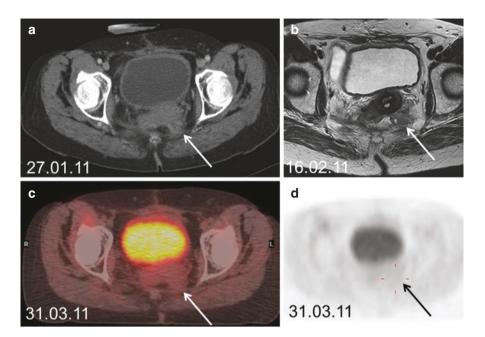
Role of FDG PET-CT in recurrent colorectal cancer. 61-year-old female with rectal carcinoma treated with long course chemoradiotherapy followed by low anterior resection. Follow up axial contrast enhanced CT (a) showed indeterminate nodular soft tissue in the left posterior pelvis (arrow). Subsequent MR (b) also revealed an ill-defined soft tissue at this site with heterogeneous signal (arrow in b), Local recurrence could not be excluded and a CT guided biopsy was being considered. Following MDT discussion radiologist advised a PET-CT prior to attempting biopsy. This clearly showed that the area of concern did not show any abnormal increased uptake (arrows in c and d). Findings were in keeping with a benign abnormality. External operative notes showed at the time of surgery there was a very dense adhesion of the low rectum and the left posterolateral aspect; however, the CRM was negative and findings would be in keeping with a resolving haematoma. This was proven on follow up. FDG PET-CT has a high negative predictive value for recurrent disease and in this case helped avoid an unnecessary biopsy
